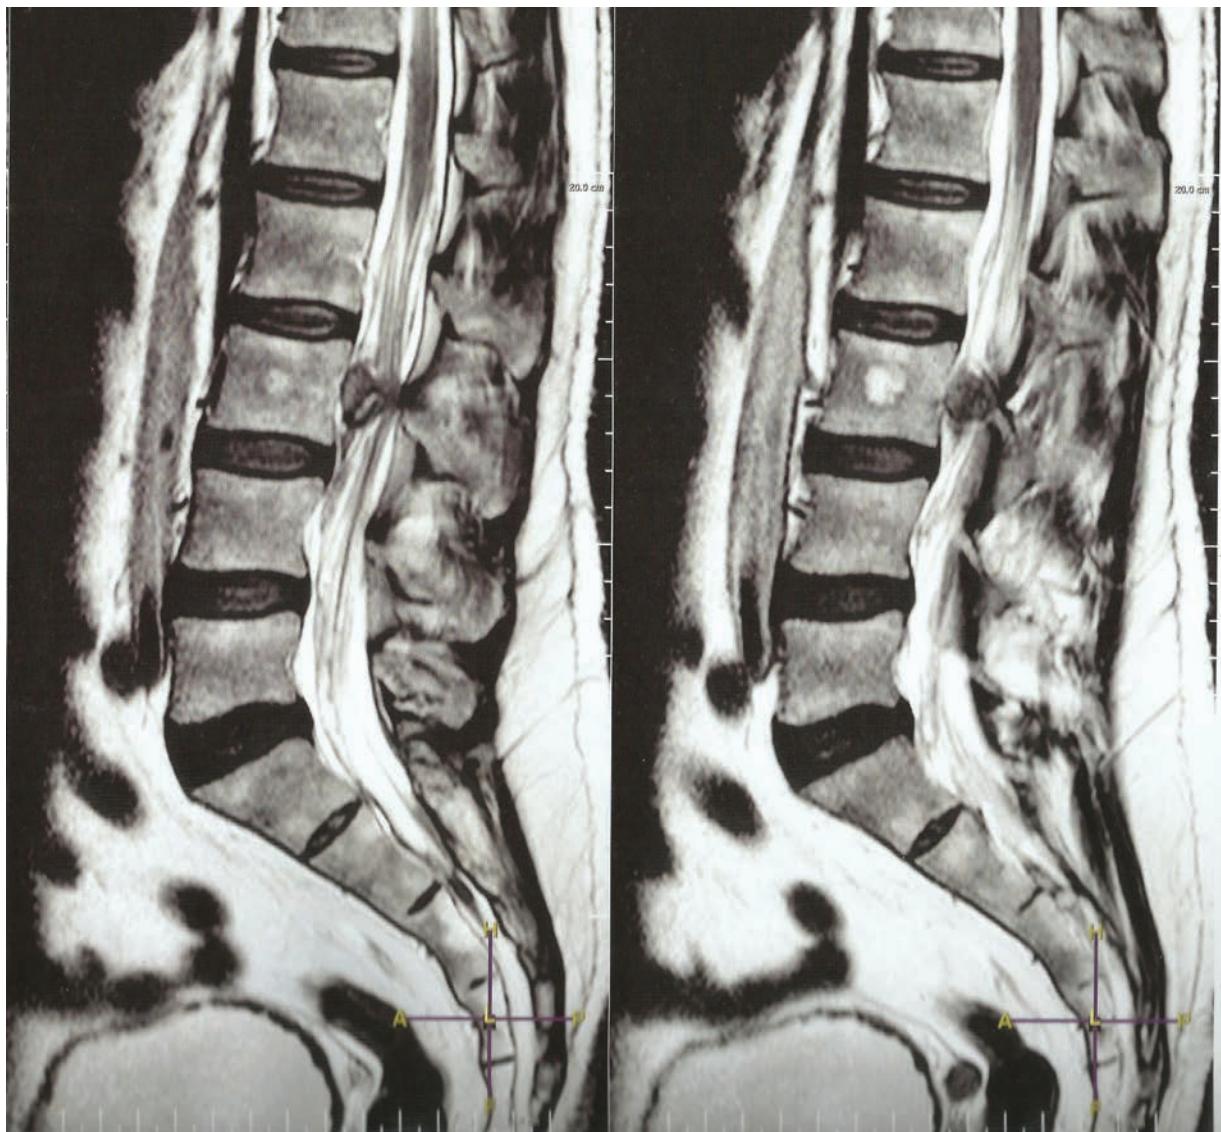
Sagittal T2-weighted lumbosacral magnetic resonance imaging highlighting the intradural extramedullary heterogeneous expansive lesion located posterior to the L3 vertebral body and projecting to the L3-L4 right foramen.
